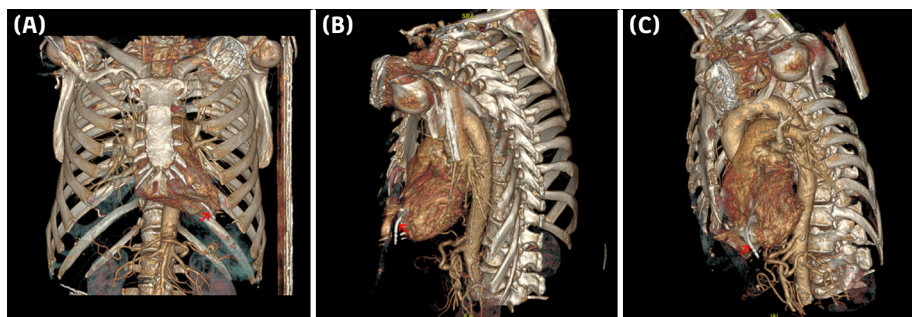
Three-dimensional volume-rendered computed tomography images (A-C) showing the implantable cardioverter-defibrillator (ICD) lead (red arrows) perforating the right ventricular apex.
